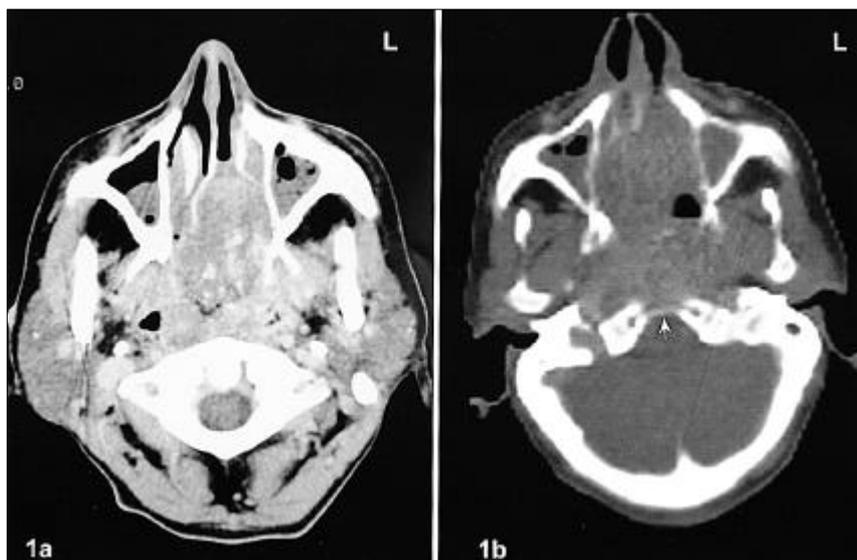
Computed tomography with contrast showing an extensive lesion filling up the nasopharynx and protruding into the left nasal cavity. Bone destruction of the clivus is evident but there is no intracranial extension.
